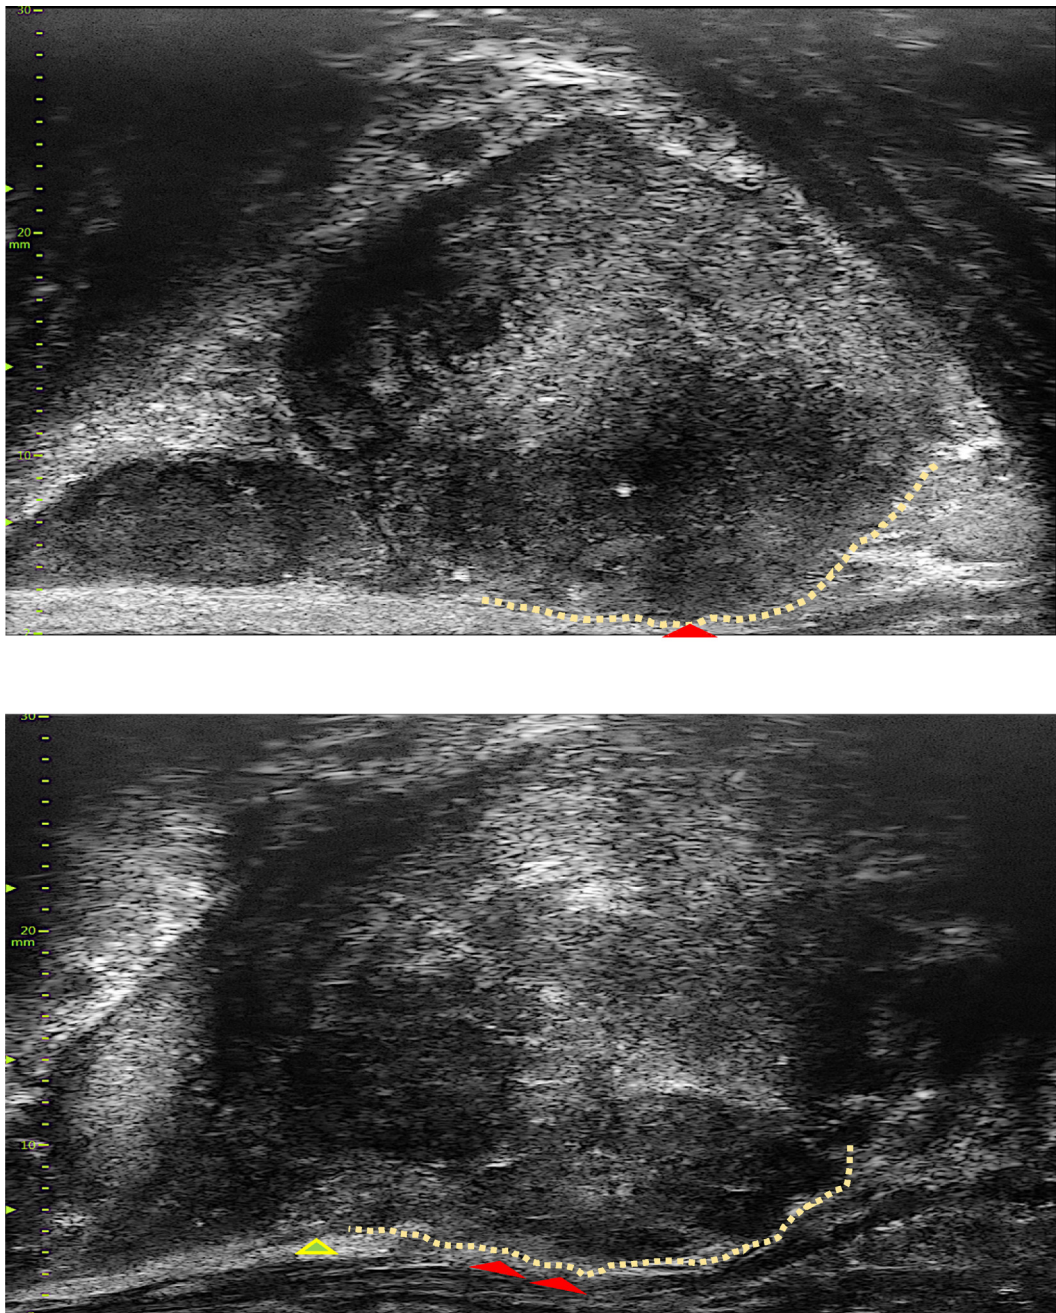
Examples of MRI-derived parameters to detect ECE with MUS: capsular contact length ≥ 15 mm, capsular bulging and irregularity (yellow dotted line), visible breach of the prostate (red arrow), and obliteration of the prostatic-seminal vesicle angle (green arrow). ECE = extracapsular extension; MRI = magnetic resonance imaging; MUS = microultrasound.
